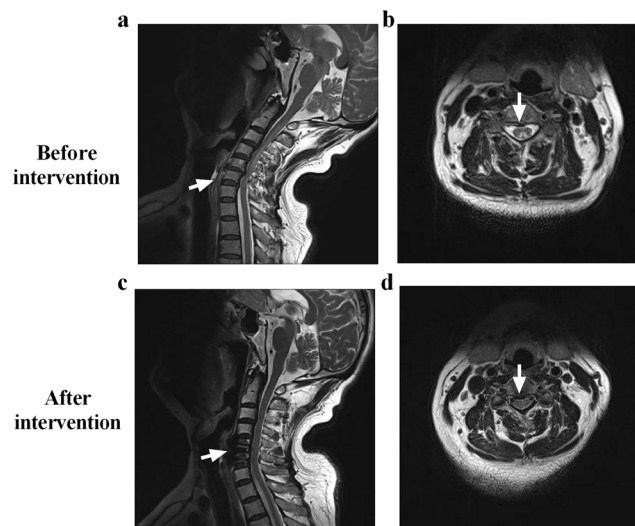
MRI of a patient presenting with subacute combined degeneration before and after intervention. The patient presenting with SCD depicts hyperintensity involving the posterior part of the cervical spinal cord on sagittal (a) image and inverted “V” sign on axial section (b, arrow). After intervention, there was disappearance of the hyperintensity involving the posterior part of the cervical spinal cord on sagittal (c) image and inverted “V” sign on axial section (d, arrow)
